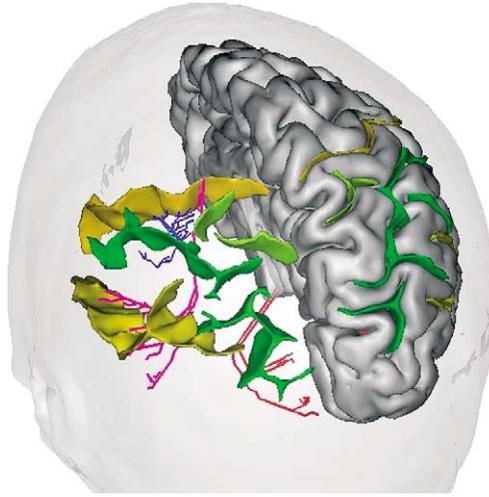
Toward the inference of the matrix of connectivity of the main cortical gyri using MRI (green to orange: cortical sulci stemming from T1-weighted images [58]; blue to red: putative fiber bundles stemming from diffusion-weighted images connecting two different gyri [54]).
